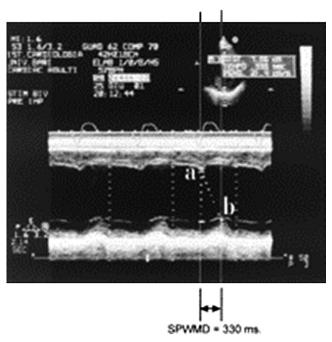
M-mode recording taken from the literature describing the time interval to be measured for identifying a patient suitable for resynchronization therapy. The time interval is from the early systolic "beak" to the peak upward motion of the posterior wall in this patient with LBBB. (From Pitzalis MV, Iacoviello M, Romito R, Massari F, Rizzon B, Luzzi G, et al. Cardiac resynchronization therapy tailored by echocardiographic evaluation of ventricular asynchrony. J Am Coll Cardiol 2002;40:1615-22.).
